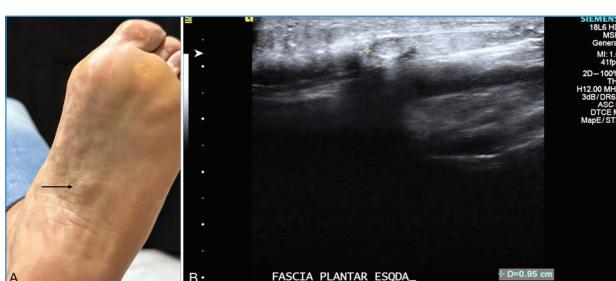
(Case 1): A - nodular lesion in the plantar surface of the left foot (arrow). B - musculoskeletal ultrasound of the left plantar aponeurosis (Siemens Acuson S-2000MT device, 18 MHZ transducer, longitudinal view): presence of an iso-hypoechoic lesion with well-defined borders adjacent to the plantar aponeurosis, with 0.95 cm of longitudinal diameter, without power doppler signal, suggestive of a plantar fibroma.
